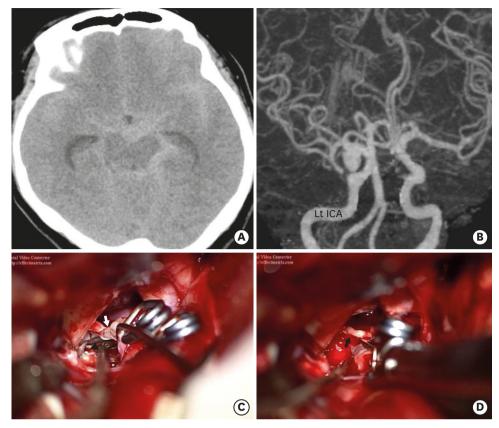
(A) CT reveals thick subarachnoid hemorrhage and hydrocephalus. (B) CT angiogram depicts an 8×6 mm size aneurysm in the left posterior communicating artery. (C) The ON (white arrow) is pinched between the tips of clip (black arrow head). (D) Photography demonstrates the ON has its anatomical continuity with focal thinning (black arrow).
